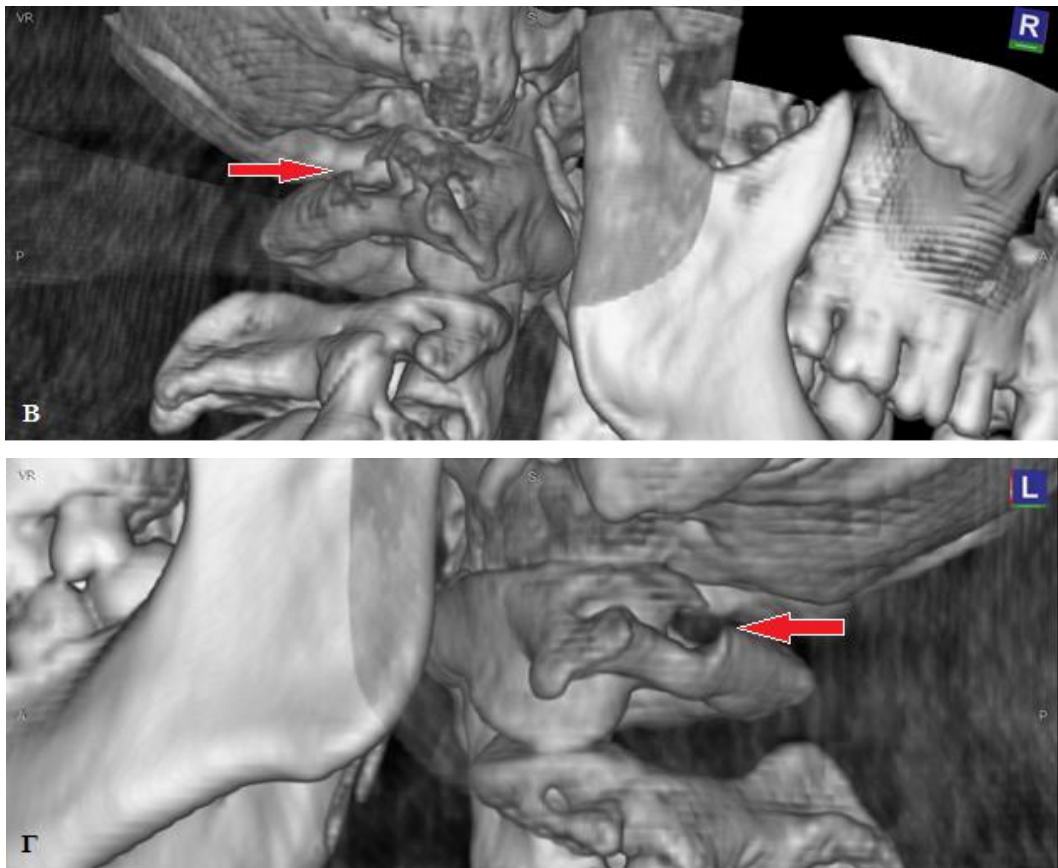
Computed tomography with 3D reconstruction. Craniocervical articulation: A) rear complete Kimmerle ring on the right, B) posterior complete ring C1 on the left, C) posterior incomplete ring C1 on the right, D) posterior incomplete ring C1 on the left (indicated by arrows)
